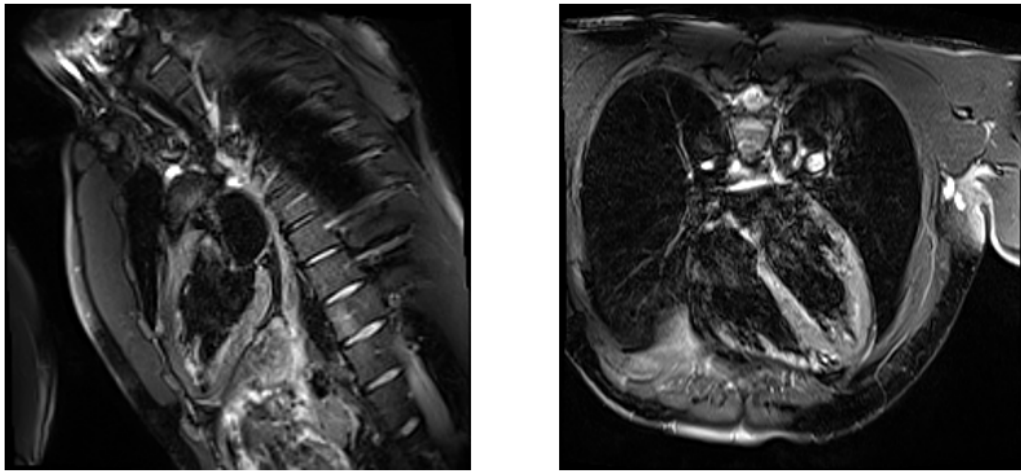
Black-blood orthogonal MRI of volunteer seven. (Left) Two chamber view. (Right) Four chamber view
